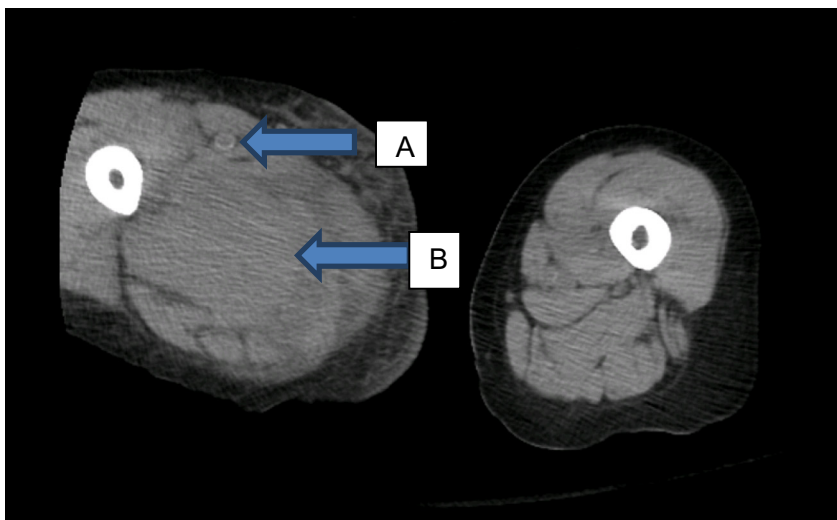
CT scan of right thigh, arrow A indicating calcified vessel, arrow B indicating hematoma.
